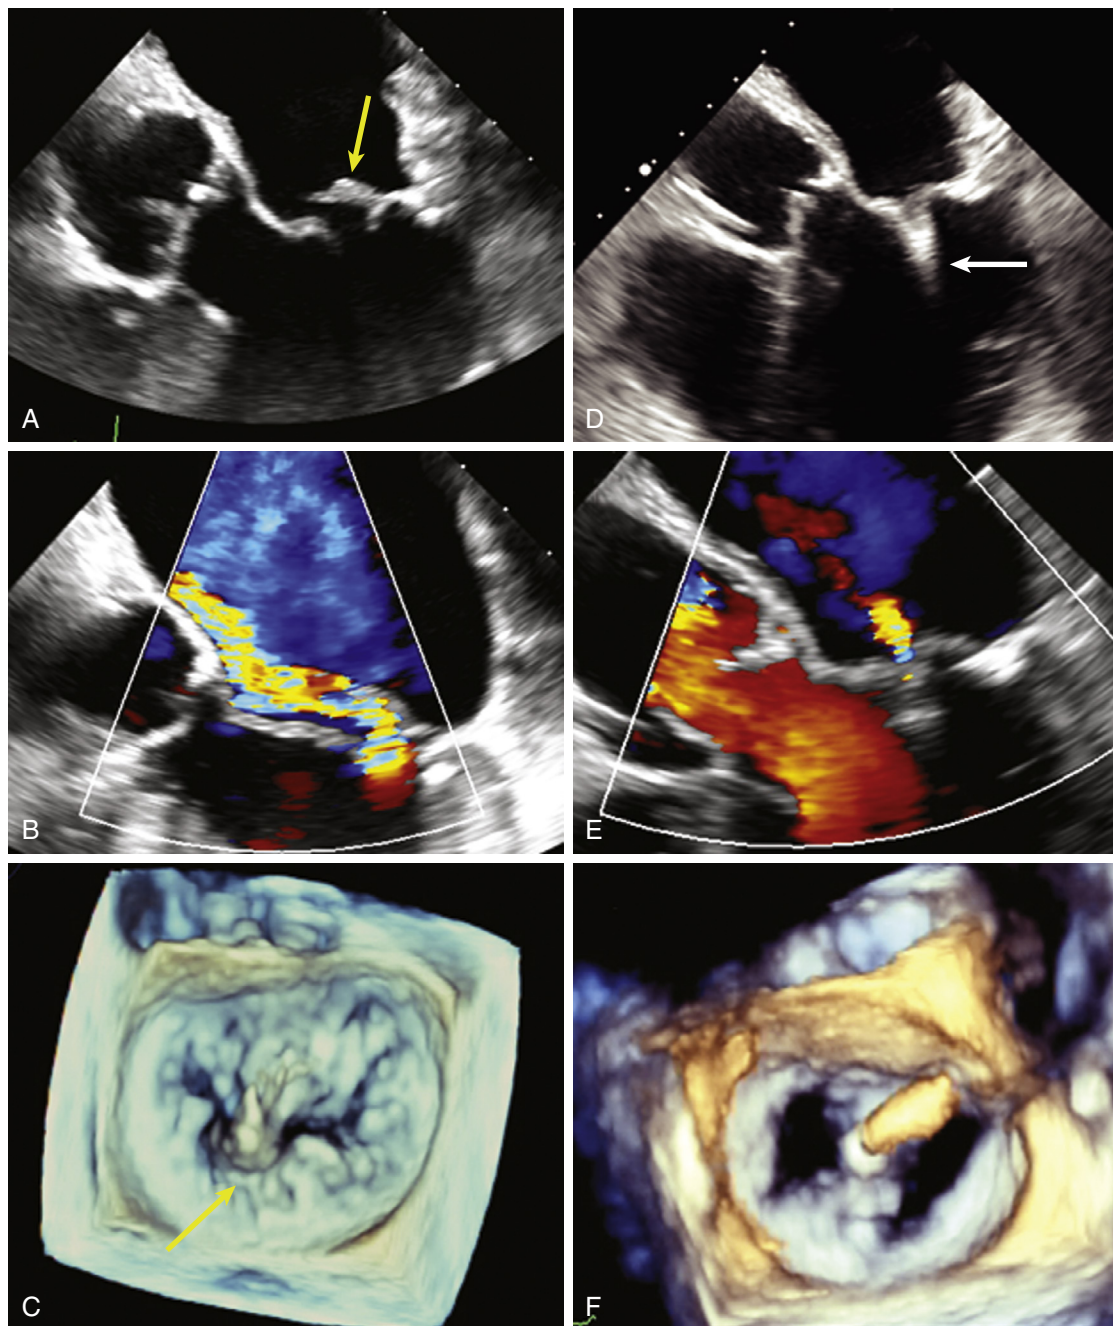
MitraClip repair of posterior mitral valve leaflet flail. 2- and 3-D TEE images in a patient with posterior mitral leaflet flail (Left panels, yellow arrows) followed by MitraClip placement (Right panels, white arrow). A, Posterior leaflet flail segment with ruptured chordae. B, Corresponding eccentric severe MR. C, 3D TEE view as viewed from the left atrial aspect; D, MitraClip is seen attached to both leaflets in the LV. E, with reduced MR on color Doppler. F, 3D TEE view of the double orifice created by the MitraClip (note the delivery catheter is still attached on the left atrial side. (See corresponding Videos 16.66 for pre-MitraClip and 16.67 post-MitraClip.)
